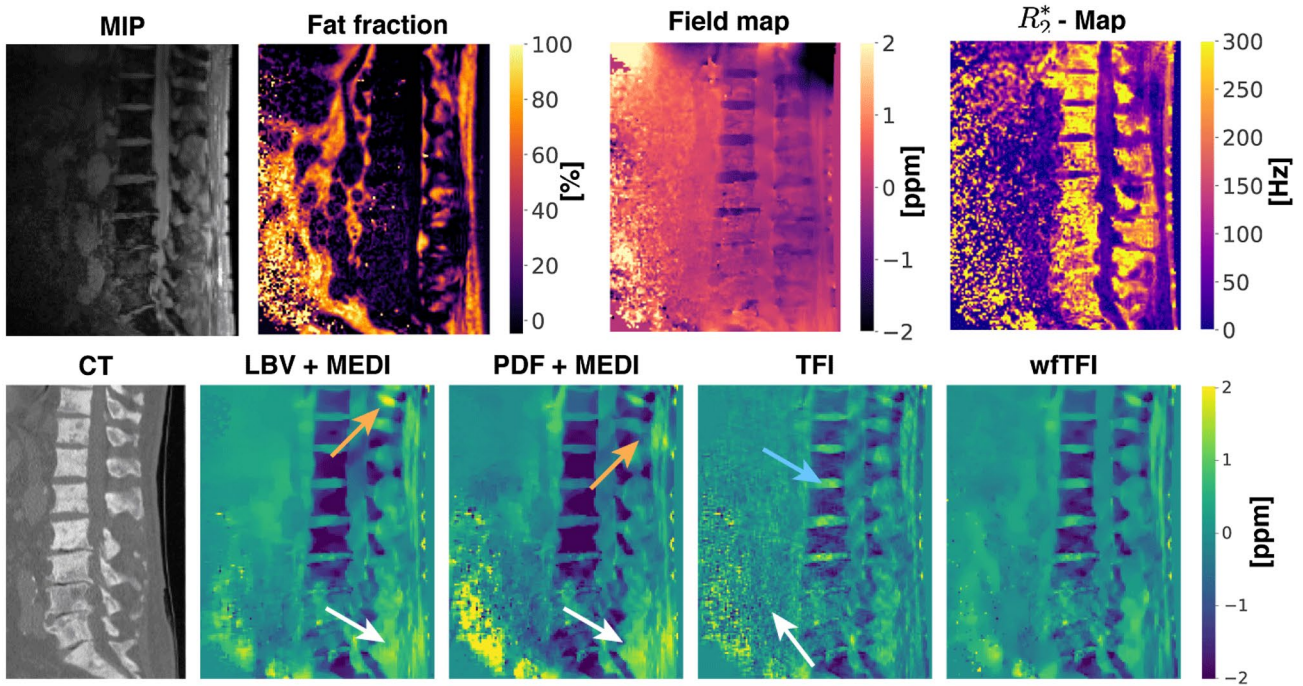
Results of water-fat imaging (first row), CT (bottom left image), and QSM (second row) in a subject with mainly osteoblastic bone metastases. The fat fraction and R_2^* -map indicate a pathological change of the vertebral bodies by showing significantly reduced fat fraction and elevated R_2^* values, respectively. In the estimation of the vertebral body susceptibility, all 4 QSM methods agree very well with the CT scan. However, the BFR + LFI methods show severe BFR artifacts, especially in the spinous process region of the T10 and T11 vertebra (orange arrows) in the LBV and PDF based maps, respectively, and the fat region in the height of the L5 vertebra (white arrow). The TFI method shows significant noise amplification in the anterior to the spinal cord (white arrow) and artifactual strong paramagnetic susceptibility values in all IVDs (blue arrow). The wfTFI shows no noise amplification, no BFR artifacts, and reduced artifactual paramagnetic elevation in the IVDs
